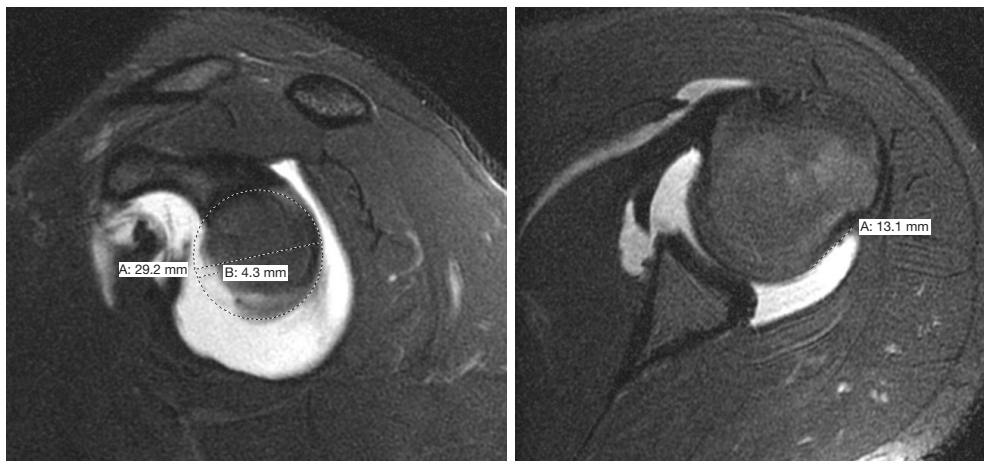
“Near-track” lesion. Glenoid track calculated on sagittal MRI cut on left as $0.83 \times (29.2 \text{ mm}) - 4.3 \text{ mm} = 19.9 \text{ mm}$; Hill-Sachs interval measured at 13.1 mm on the axial MRI cut on right. “DTD” calculated as (glenoid track) – (Hill-Sachs interval); $19.9 \text{ mm} - 13.1 \text{ mm} = 6.8 \text{ mm}$ DTD. DTD <8 mm = “near-track” lesion. MRI, magnetic resonance imaging; DTD, distance to dislocation.
